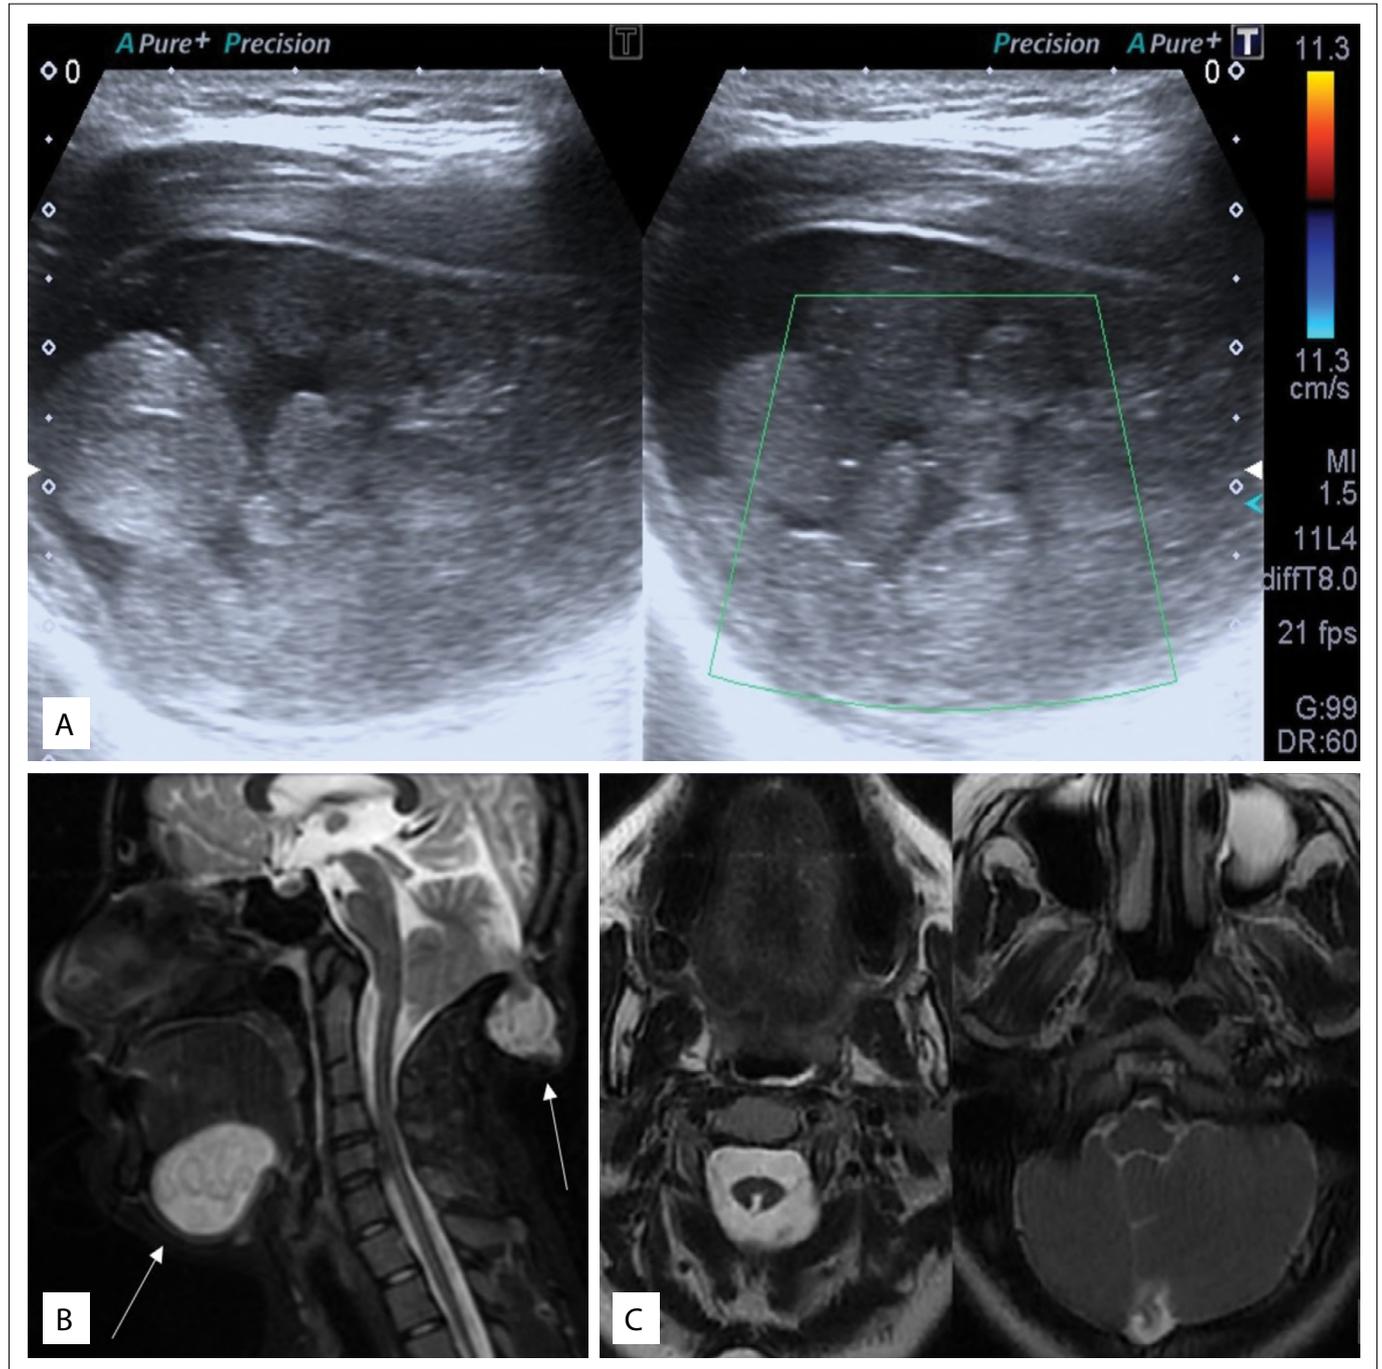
(A) Sonography images showing an oval-shaped, thick-walled cystic lesion. Solid nodular appearance can be seen, without blood flow on color doppler ultrasonography, thus revealing the “sack of marbles” sign. (B) Sagittal T2W Fat Sat image showing hyperintense cystic mass at the base of the mouth, cerebellar meningoencephalocele, tonsillar herniation and C2-C3 vertebral fusion. (C) Axial T2-weighted images demonstrating dysgenesis of the right cerebellum, hypogenesis of the vermis and short-segment posterior myelosis at the cervicomedullary junction.
